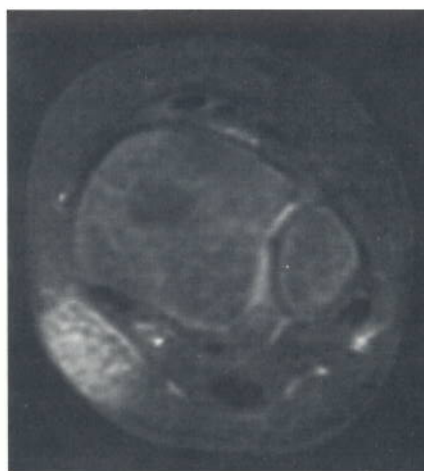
After removing the skin marker, the post-gadolinium transverse T1-weighted FatSat scan was repeated, and this demonstrated that the unknown dark area had disappeared.
